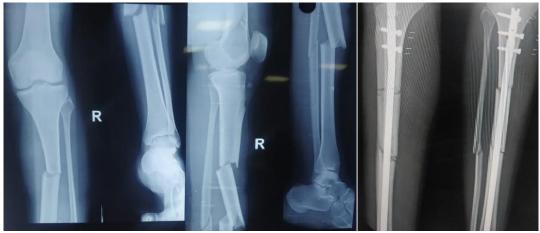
Preoperative and Postoperative Xray Showing Segmental Tibial Shaft Fracture Fixed with Tibial Nailing by Suprapatellar Approach
